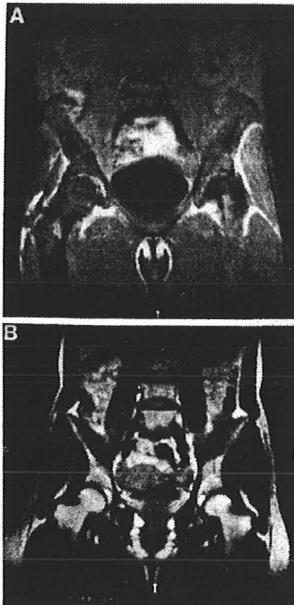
A. Coronal MRI through hip joints in a patient with CGL, showing absence of perinephric and retroperitoneal fat. Fat is present in peri-articular region near hip joint, and in the perineum, but is notably absent in the other subcutaneous areas. Medullary signal intensity is decreased in the visualized bones. B. Similar image from a normal healthy female, showing subcutaneous and intermuscular fat, particularly in the gluteal region. Fat is also noted in the retroperitoneal region, periarticular region near hip joint, in the perineum, and in the perirectal region.
